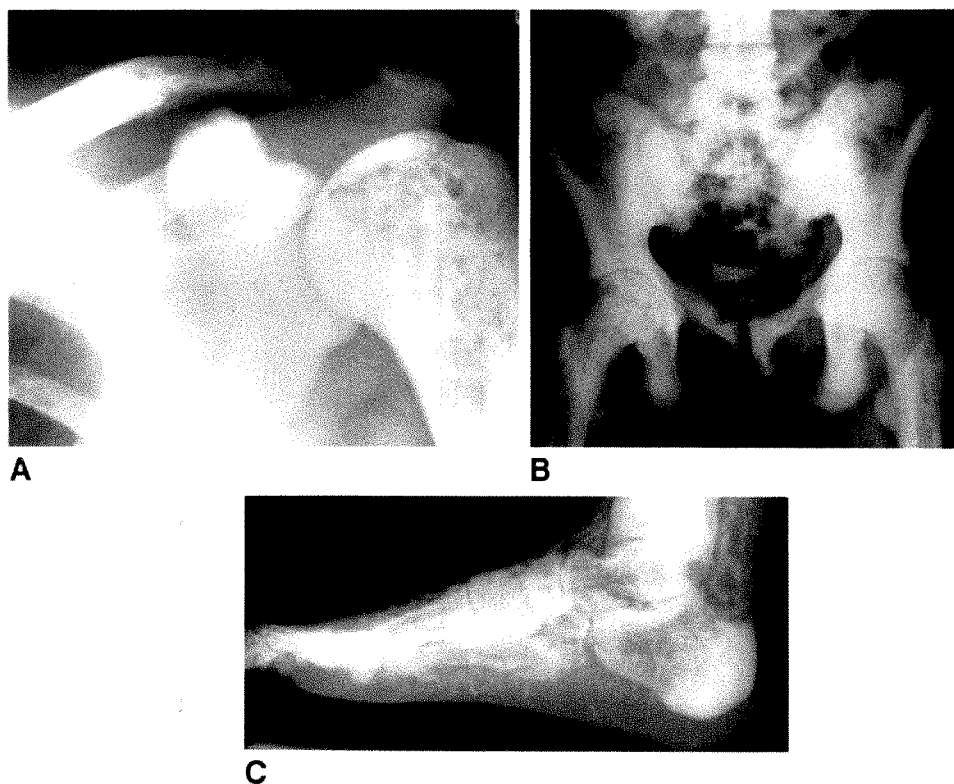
Case 3: 29-year-old woman with deteriorating health. A, Radiograph of left shoulder. B, Radiograph of pelvis. C, Radiograph of right foot.
